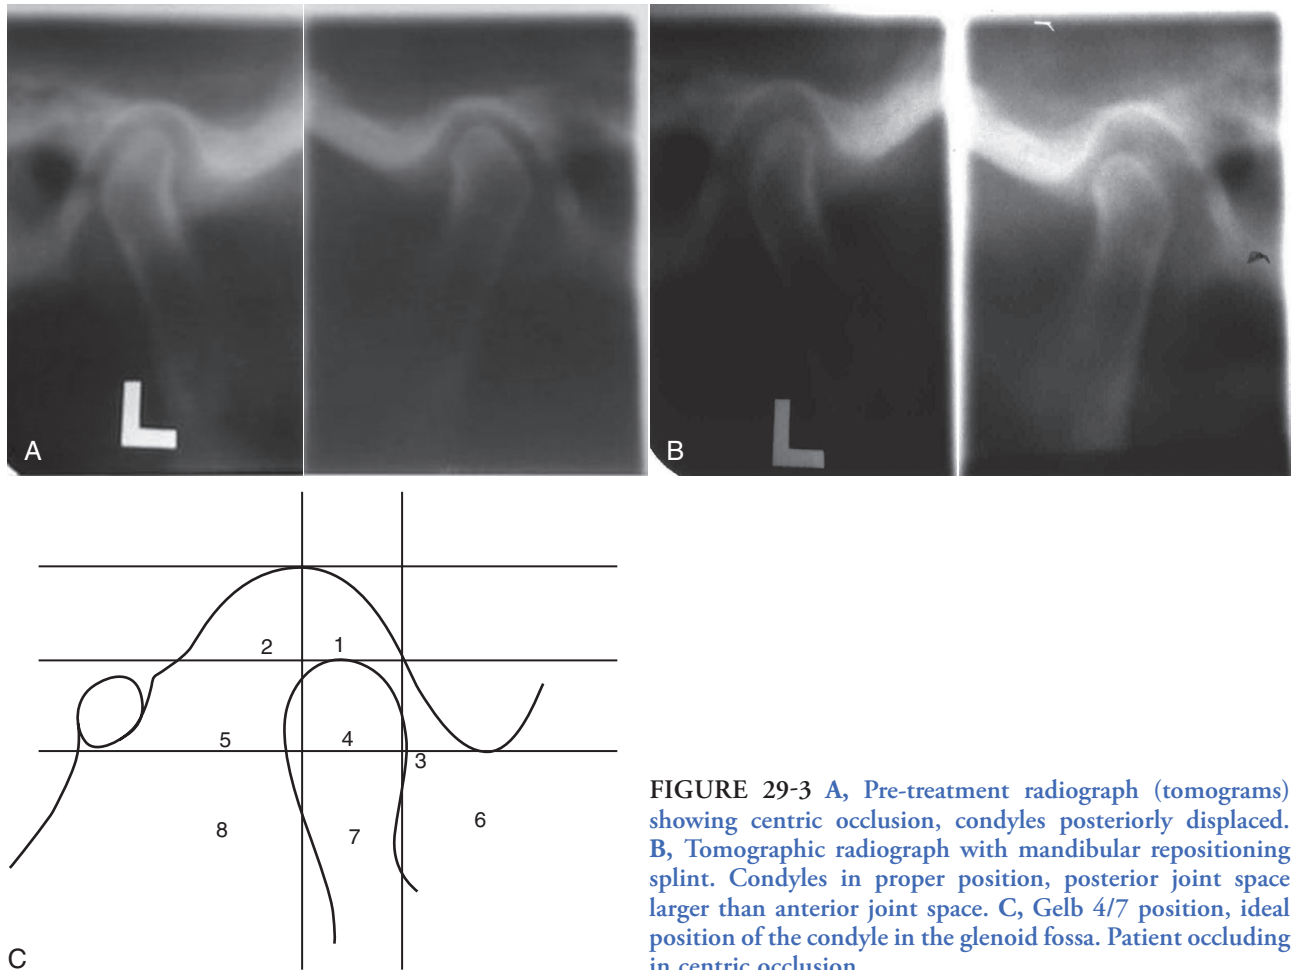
A, Pre-treatment radiograph (tomograms) showing centric occlusion, condyles posteriorly displaced. B, Tomographic radiograph with mandibular repositioning splint. Condyles in proper position, posterior joint space larger than anterior joint space. C, Gelb 4/7 position, ideal position of the condyle in the glenoid fossa. Patient occluding in centric occlusion.
